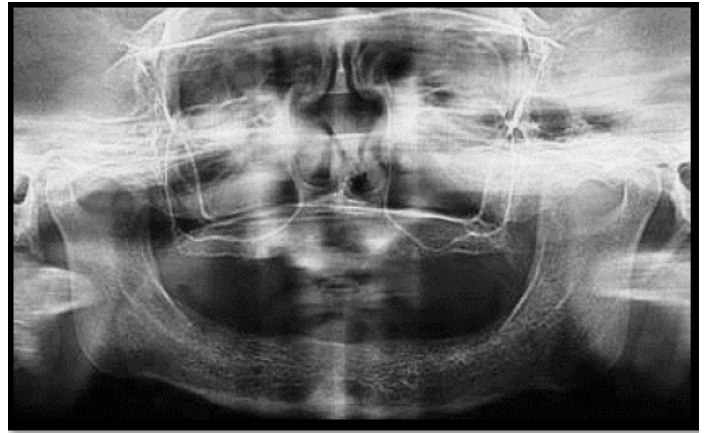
a: Preoperative OPG radiograph
